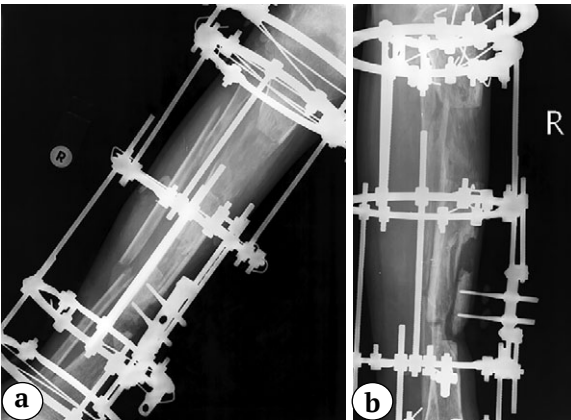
X-rays of the patient's lower leg in frontal and lateral projections in the Ilizarov apparatus with 4 rings: a – the contact between the "split" and distal fragment of the tibia is determined; b – the reconstructed bone regenerate of the tibia in the upper third is determined
